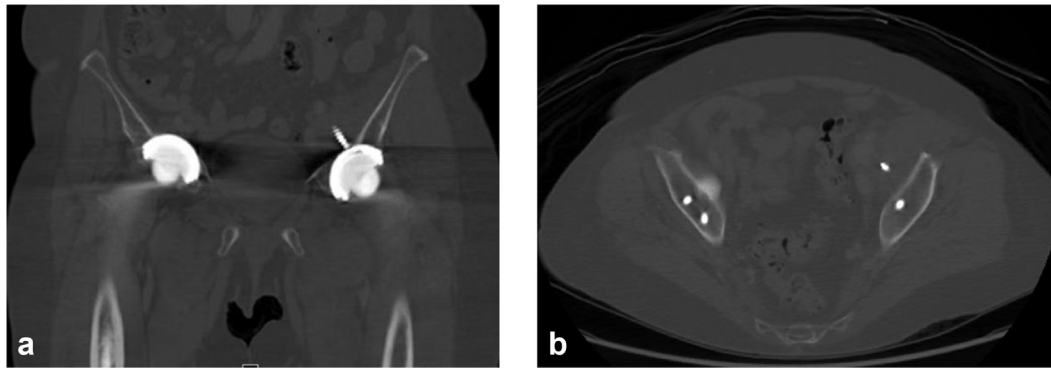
(a) Coronal cut of noncontrast CT of the pelvis demonstrating significant medial wall perforation (>2 cm) of a left-sided acetabular screw. (b) Axial cut from the same examination demonstrating the extent of medial screw penetration, and its termination in the asymmetric fullness within the left iliacus muscle.
